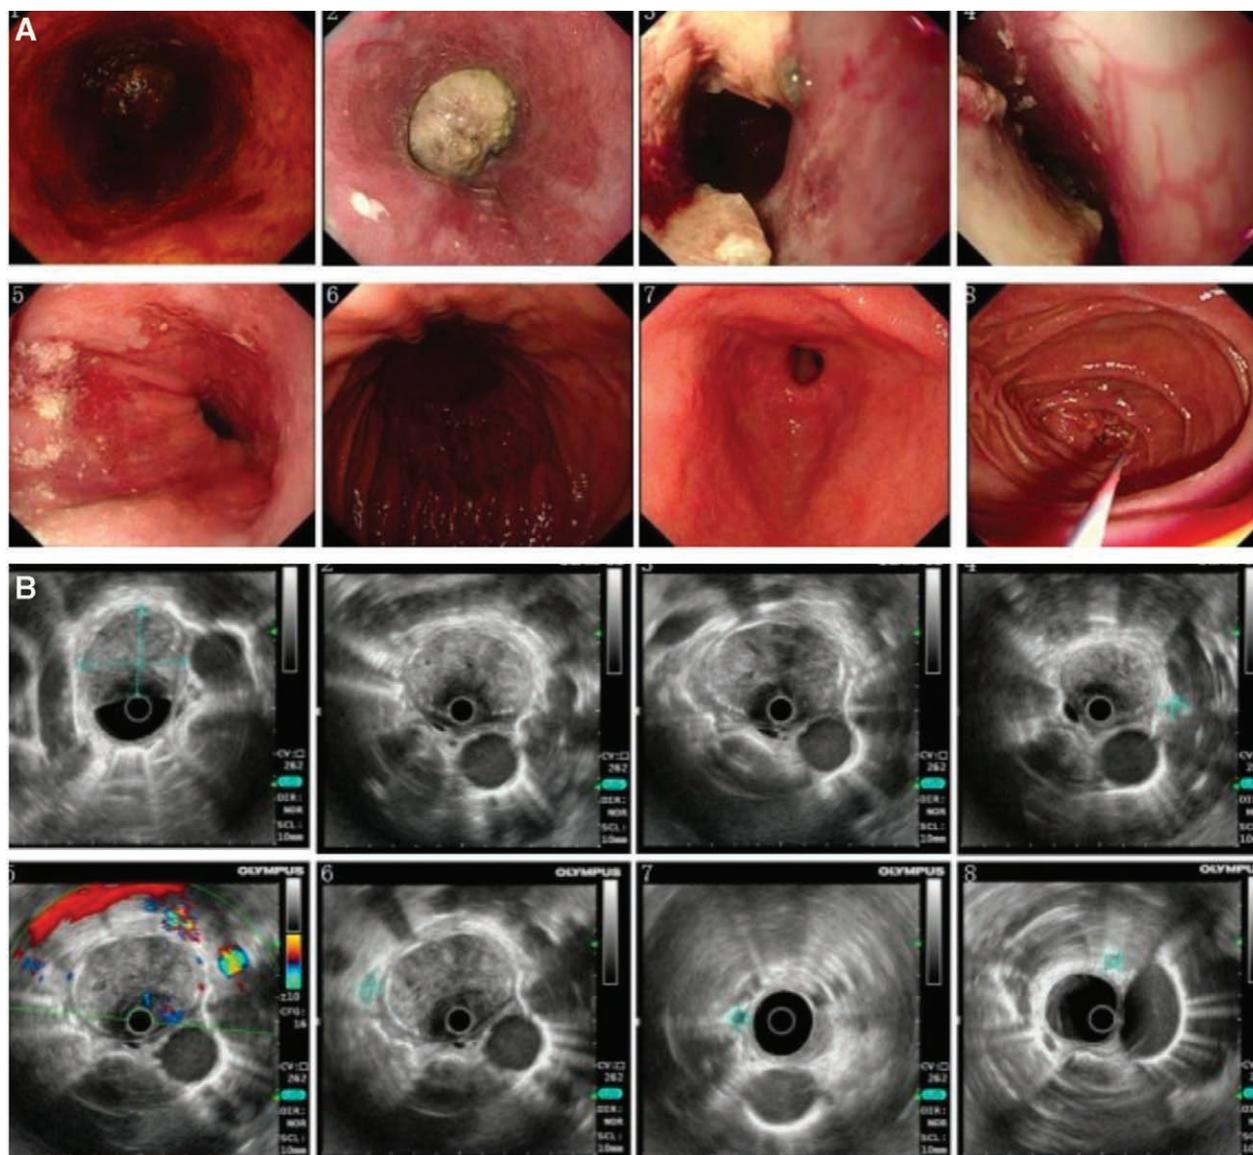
Endoscopic appearance of the esophageal tumor. (A) Esophagoscopy reveals a huge mass with an irregular surface occupying the esophageal lumen of the thoracic esophagus. (B) Esophageal ultrasonography reveals that the lesions are mainly located in the mucosal layer and submucosa, some layers are closely related to the muscularis propria and the boundary is unclear, the adventitia is intact, and the lymph nodes beside the esophagus are observed.
